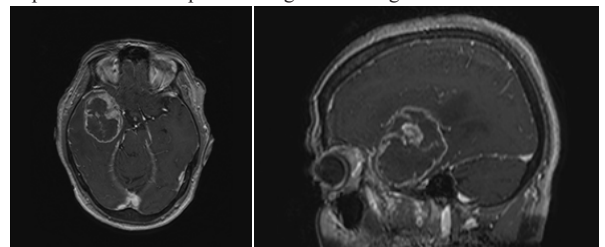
MRI images of gliosarcoma.
